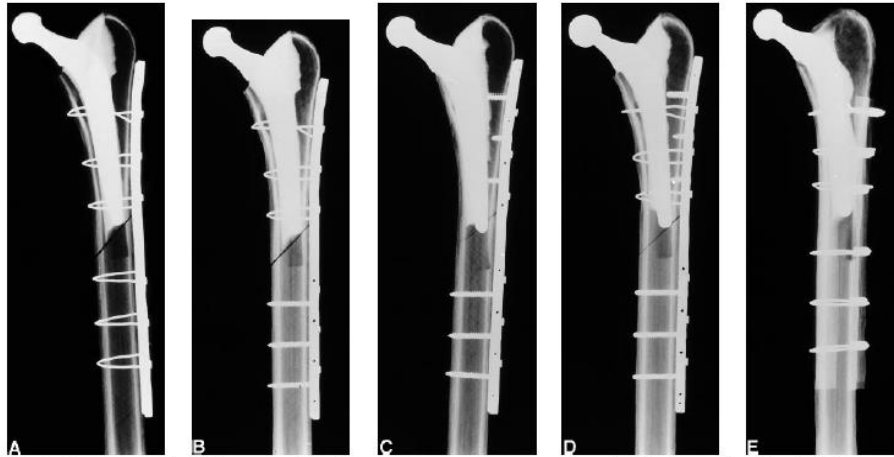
X-ray views of the 5 periprosthetic fracture fixation constructs evaluated. (A) Plate with cables. (B) Plate with proximal cables and distal bicortical screws (Ogden concept). (C) Plate with proximal unicortical screws and distal bicortical screws. (D) Plate with proximal unicortical screws and cables and distal bicortical screws. (E) Two allograft cortical strut grafts with cables.
